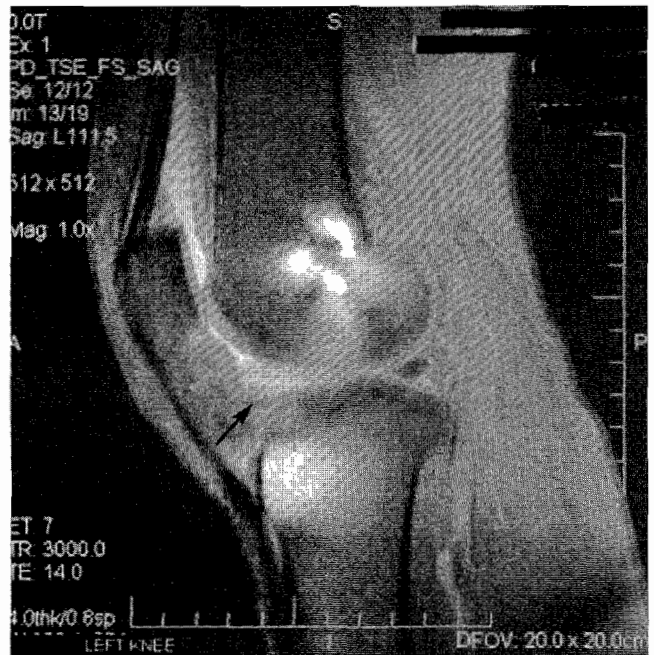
Sagittal MRI knee PD fat-saturation Cyclops lesion.
